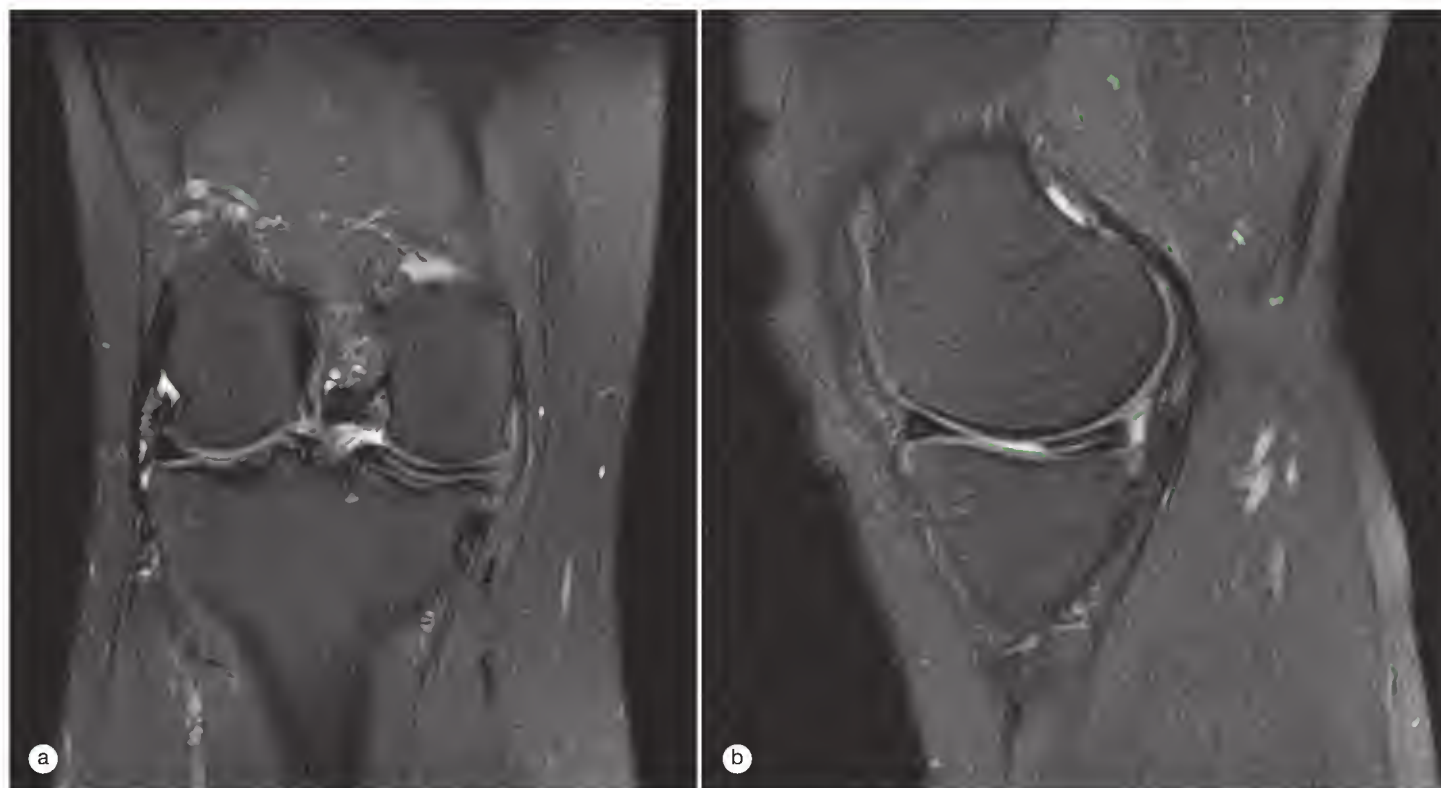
Magnetic resonance images of a degenerative medial meniscus tear in the coronal (a) and sagittal (b) views.
